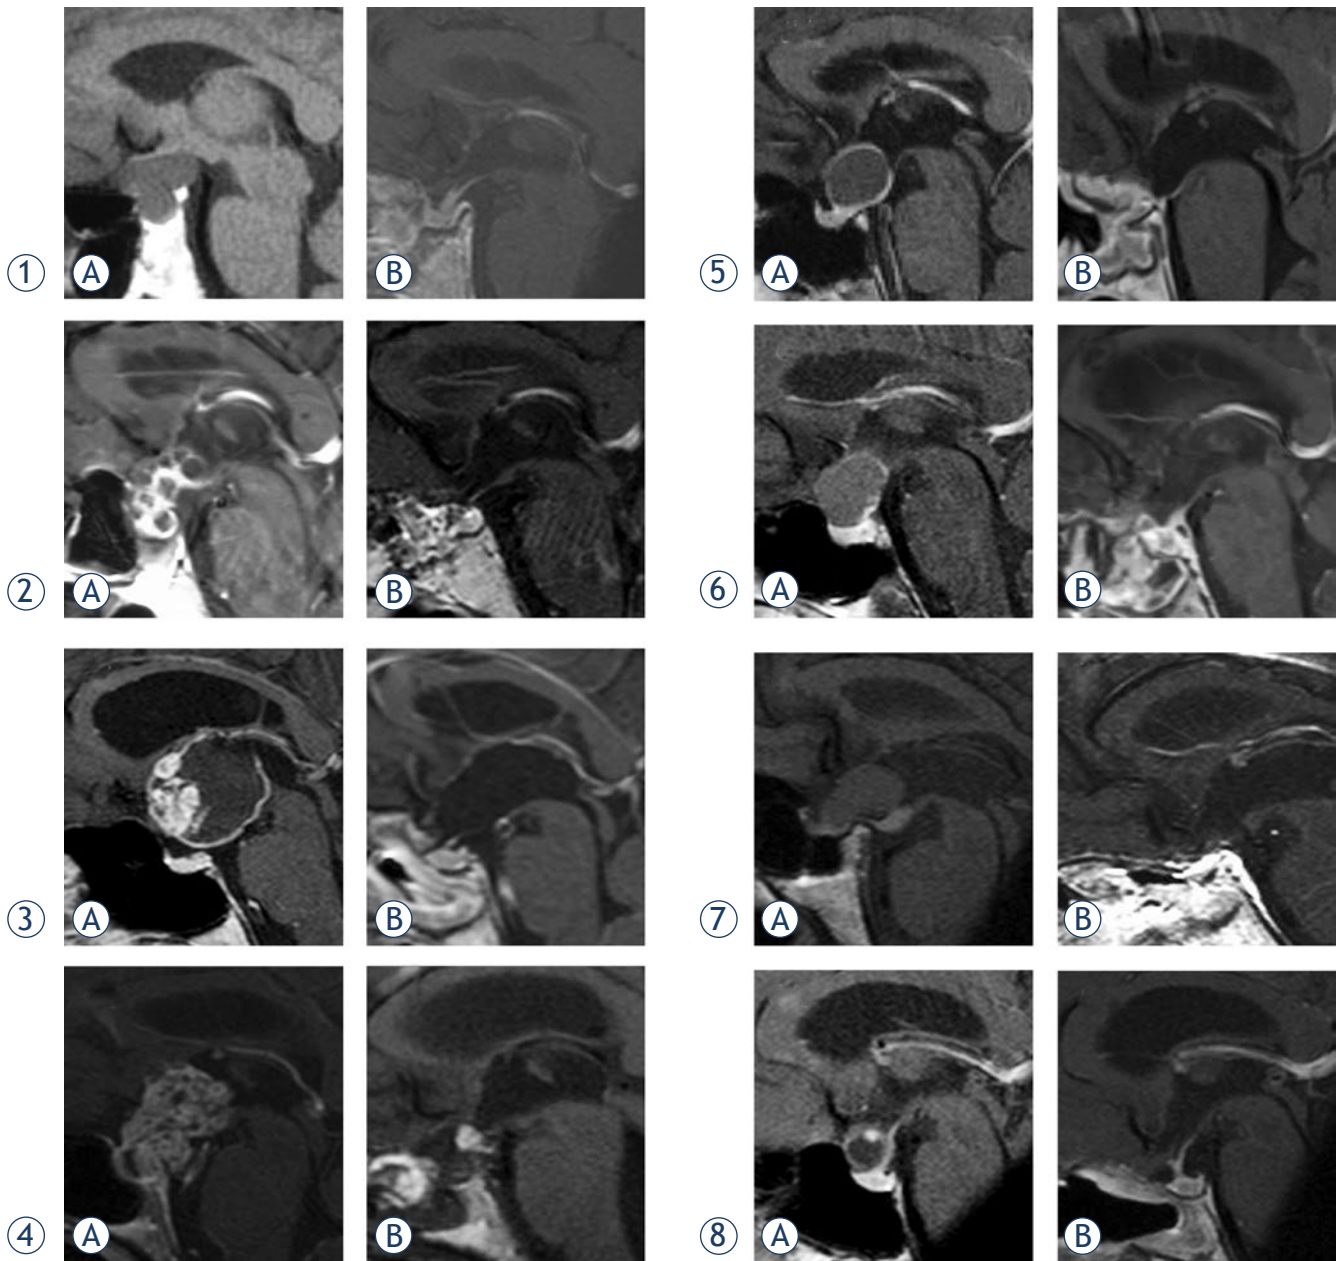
MRI scans (sagittal planes) of craniopharyngiomas in eight patients preoperatively A and postoperatively B.
